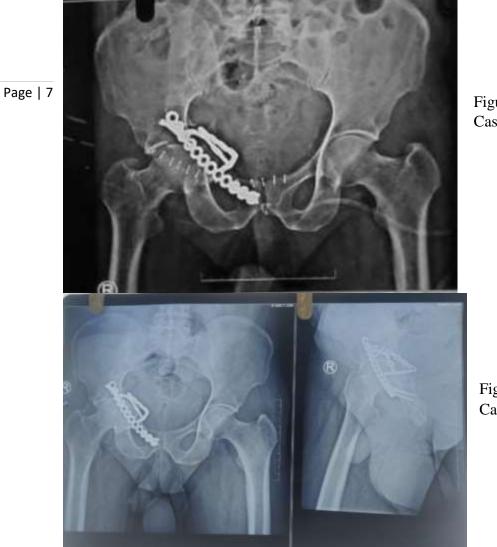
shows the Post Op Xray of Case 1
